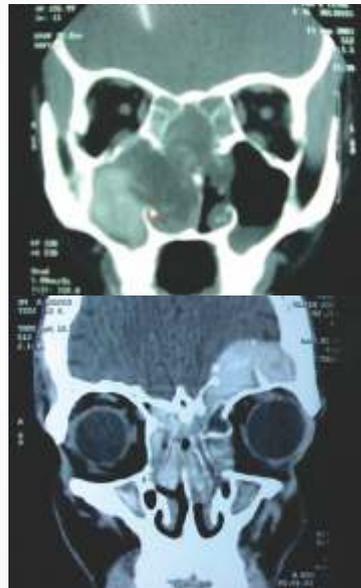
CT scan of a patient with allergic fungal rhinosinusitis
